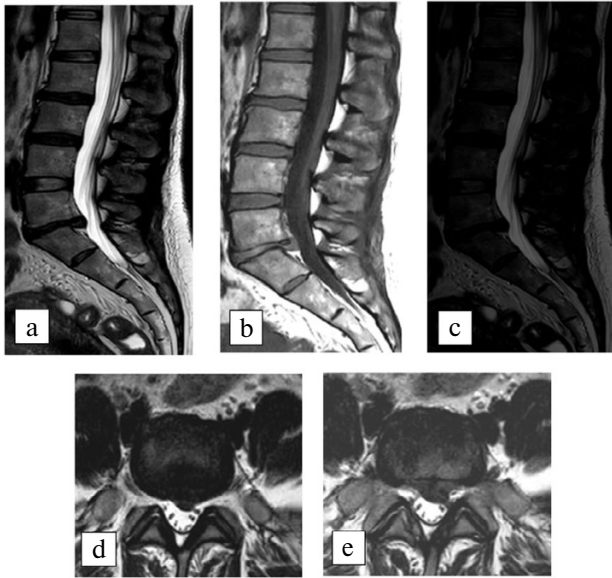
MRI scan images of the lumbosacral segment of the spine: a) sagittal MR tomogram, T2 regime; b) sagittal MR tomogram, T1 regime; c) sagittal MR tomogram, DW MRI regime; d) axial MR tomogram, T2 regime; e) axial MR tomogram, DW MRI regime.
